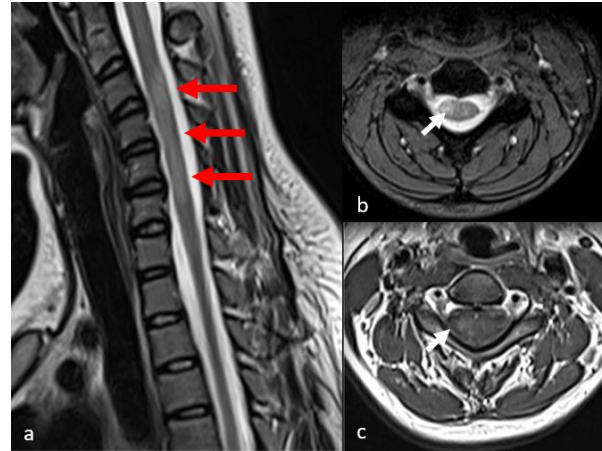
MRI of the spine in sagittal T2W (a) axial T2W; (b) and axial T1 post-contrast; (c) A long segment intramedullary lesion spans from the C3-C6 level (red arrows). The lesion was eccentrically located and enhanced post-contrast (white arrows). The spinal cord was relatively normal in size
